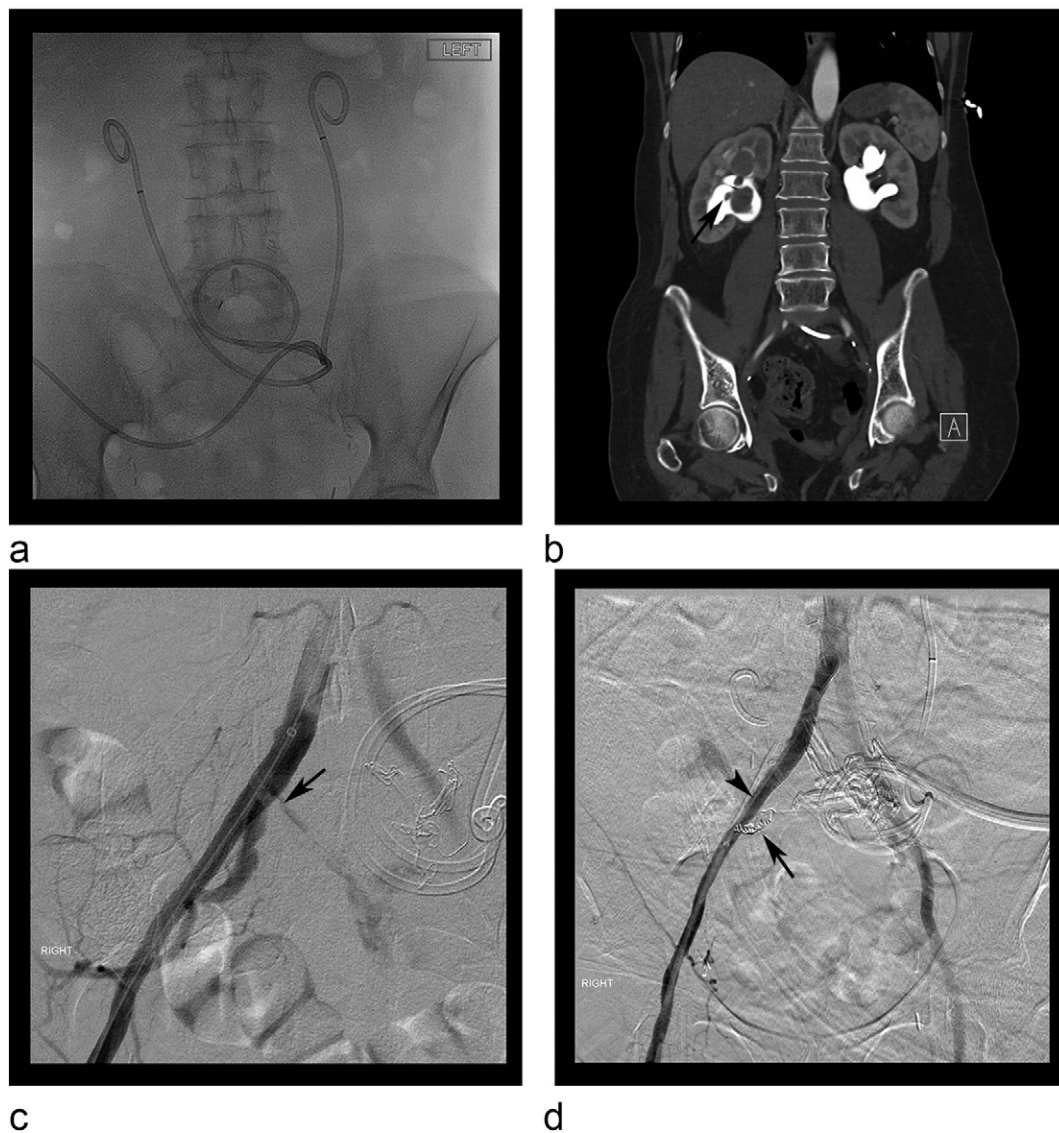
(A) Abdominal radiograph demonstrating position of bilateral retrograde ureteral stents via the DBWC. (B) Coronal CT angiogram image revealing filling defects representing blood clots in the right renal collecting system (arrow). (C) Right common iliac artery digital subtraction angiography demonstrating fistulous communication at the level of the bifurcation with the passing right ureter (arrow). (D) Successful exclusion of the ureteroarterial fistula on post contrast angiography by right common iliac artery covered stent placement (arrowhead) and coil embolization of the internal iliac artery (arrow).
